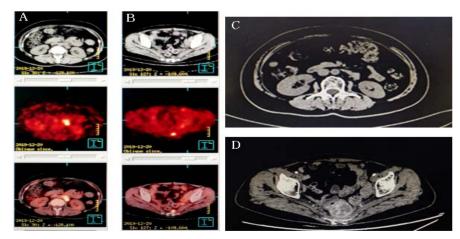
(A) PET/CT showed metastatic lymph nodes adjacent to the abdominal aorta; (B) PET/CT showed pre-sacral metastatic lymph nodes; (C) The metastatic lymph nodes adjacent to the abdominal aorta regressed after 19.2 Gy/8 fractions and 3 courses of kareolizumab outside radiotherapy; (D) The small pre-sacral lymph nodes that did not receive radiotherapy were significantly enlarged.
